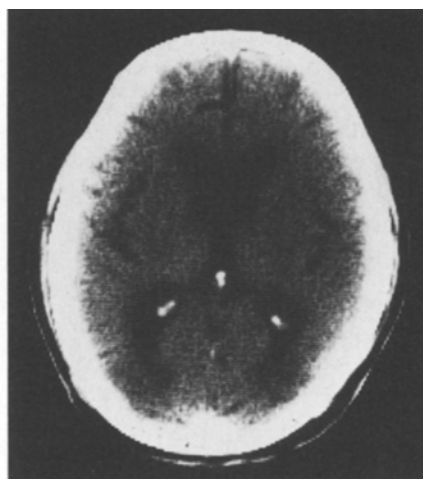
Ventricular dilatation ratio (VD ratio); the ratio of the square measures of anterior horn areas ($A + A'$) to that of the intracranial area (B), i.e. $A + A'/B$. Sulcal widening; number of visible sulci based upon CT images 50 mm distant from OML
